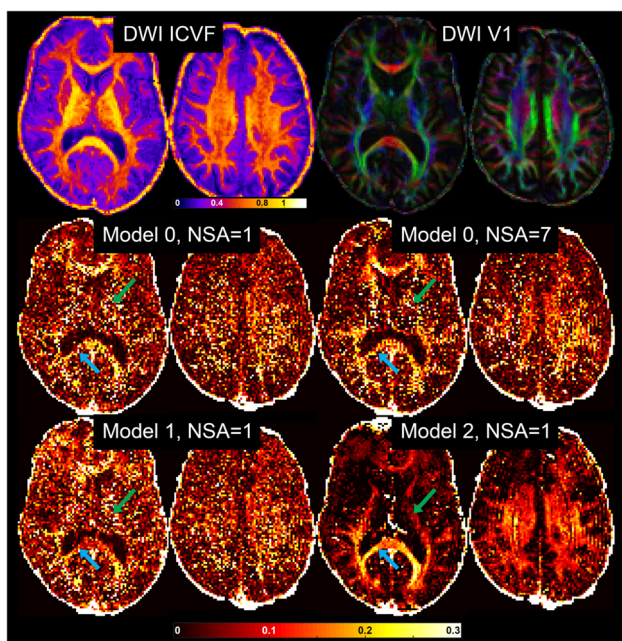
DWI and MWF results. The MWF map estimated by Model0 is noisy due to low SNR and ill conditioning of the fitting. Increasing averaging or using Model1 reduced MWF noise. Significant noise reduction can be seen on Model2 results (arrows).
